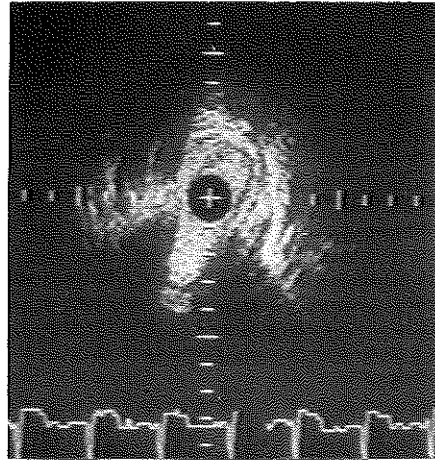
Intravascular ultrasound cross-sections obtained from a venous bypass graft that was partially obstructed by external compression at 9 o'clock. (left: normal cross-section; right: compressed cross-section). Note that blood is echogenic. Calibration 1 mm.
